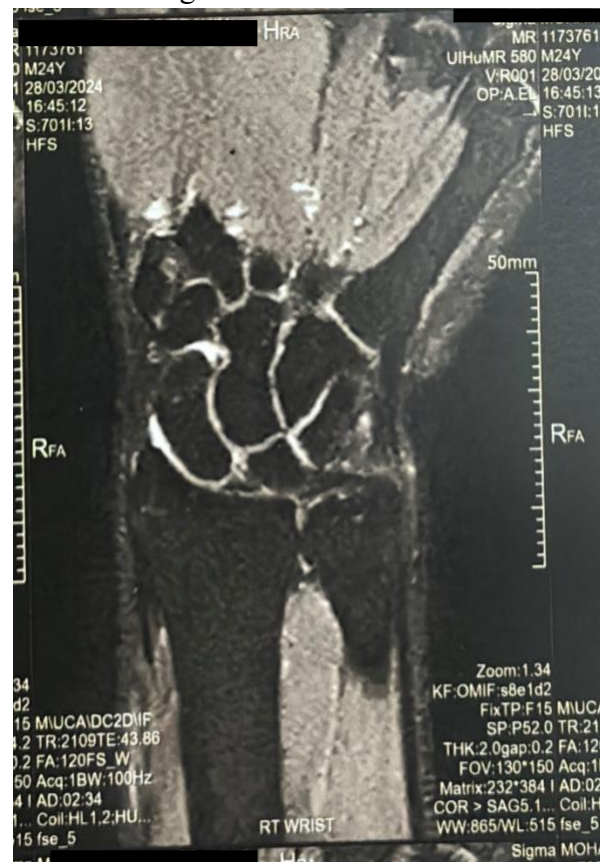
Dorsal view MRI
